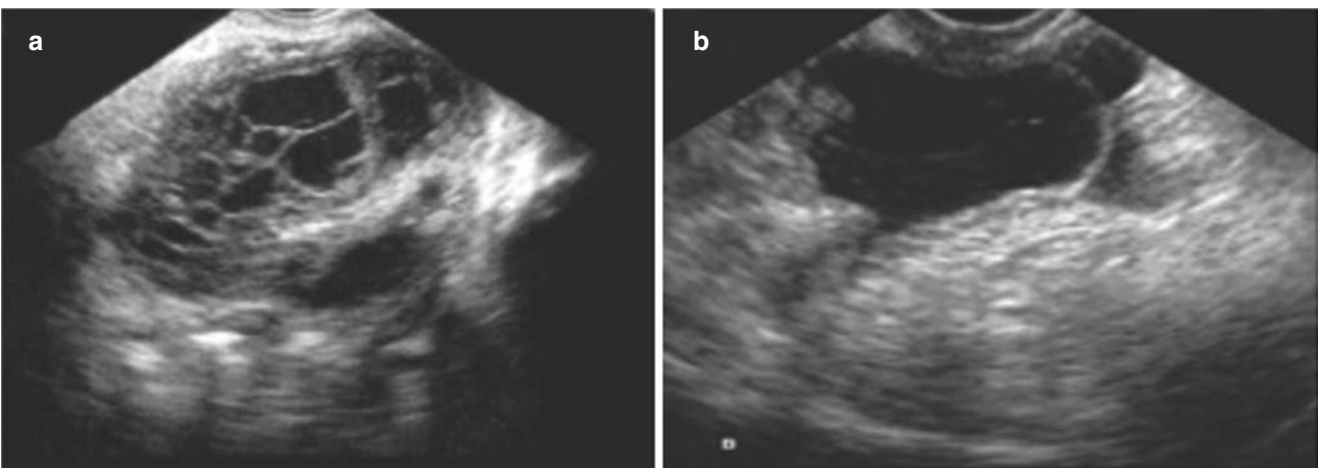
Adnexal inflammatory mass (I). (a, b) Ultrasonography shows the right adnexal septate cystic mass with irregular shape and abdominal pain. (a) Reexamination of the same patient shows the mass significantly reduced after 1 month of treatment. (b, c, d) Ultrasonic
